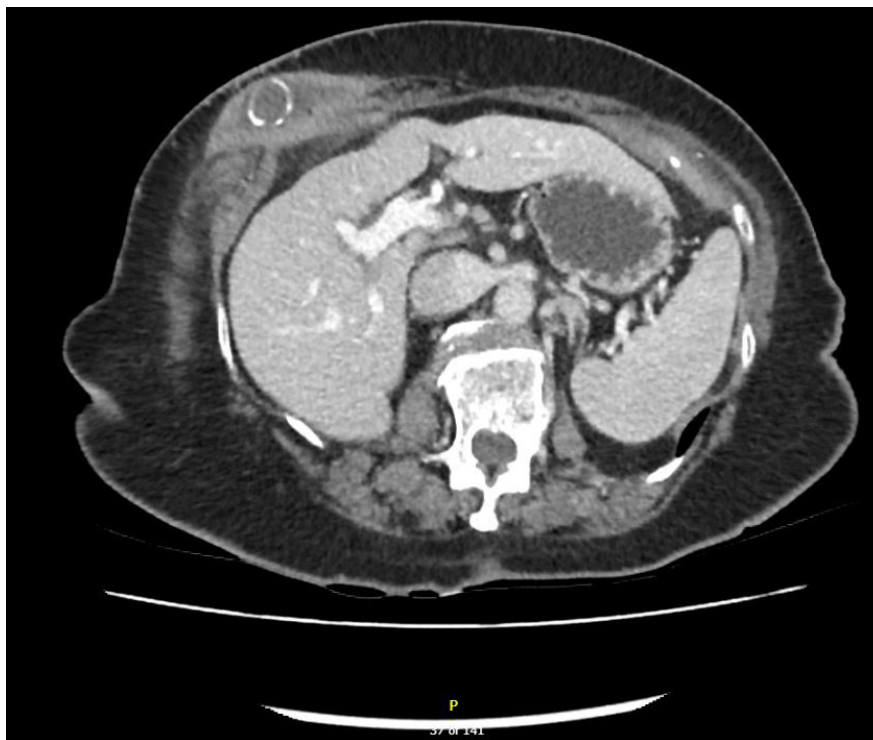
Sagittal section from computed tomography (CT) scan.
